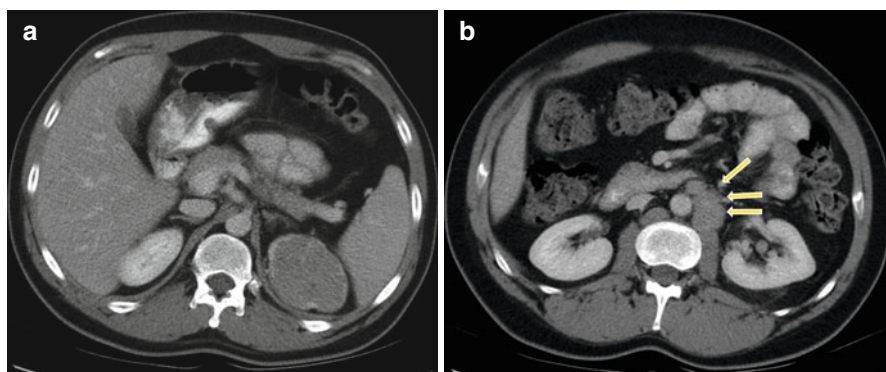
(a) Large infiltrating left kidney lesion with irregular borders. CT scan of the abdomen and pelvis in a 55-year-old male with HLRCC; this scan demonstrates a left-side kidney lesion with irregular border. (b) Left-side para-aortic lymphatic metastatic disease. CT scan of the abdomen and pelvis in a 55-year-old male with HLRCC, demonstrating para-aortic lymphadenopathy
